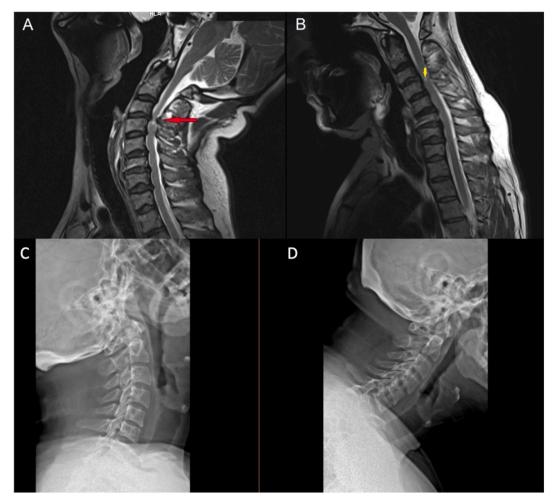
The extension (A) and flexion (B) cervical MRI in our patient which shows a bright object in cervical cord parallel to the C3-4-disc space (white arrow) and posterior cord compression in that level by folded ligamentum flavum (red arrow). Also, there is no spondylolisthesis in the extension (C) and flexion (D) cervical x-ray.
